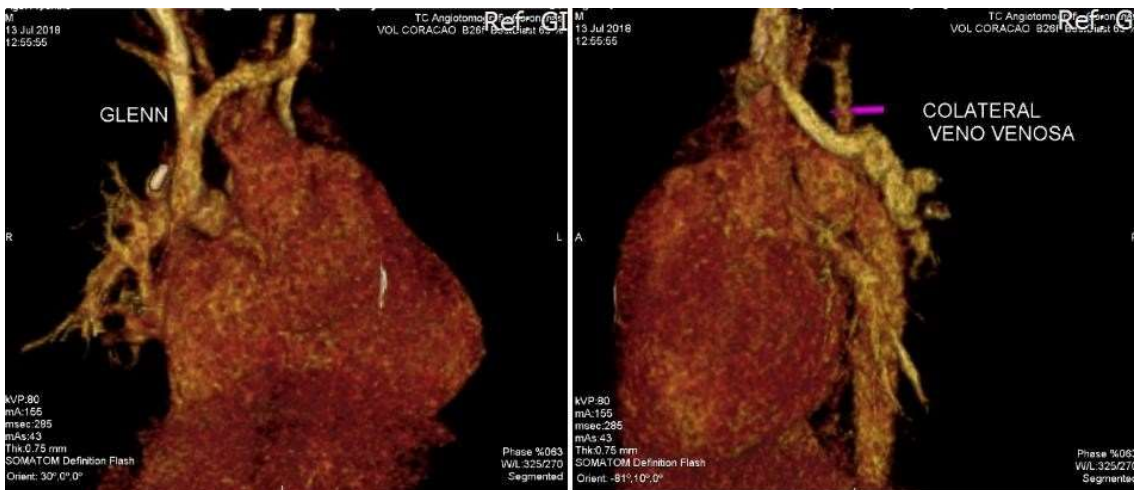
Post-Glenn CT angiography (left), showing venovenous fistula (right)
